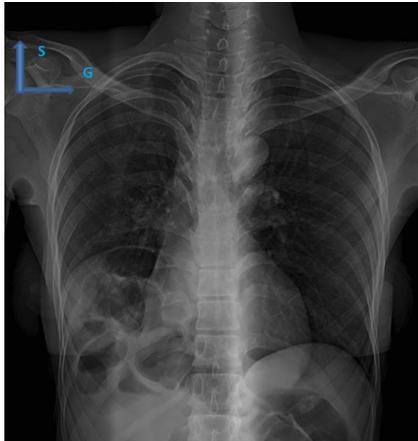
chest x-ray showing digestive loops over the liver that appear to be located in the right intra-thoracic region.
